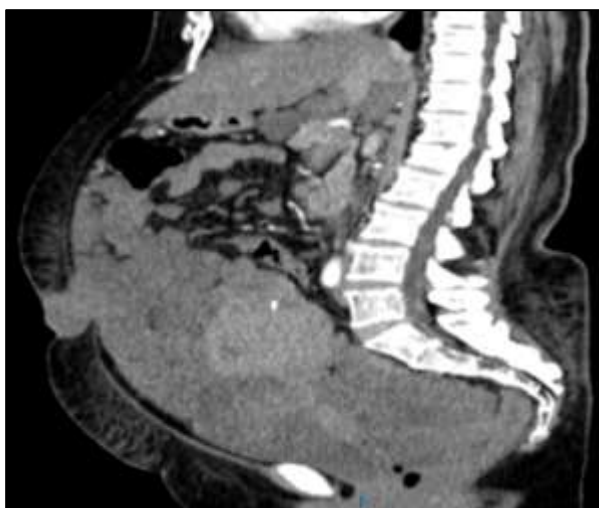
Sagittal view. CT scan showed umbilical nodule with homogeneous enhancement and 33 mm wall defect in the umbilical scar, which protrudes material with soft tissue density associated to peritoneal implants.
